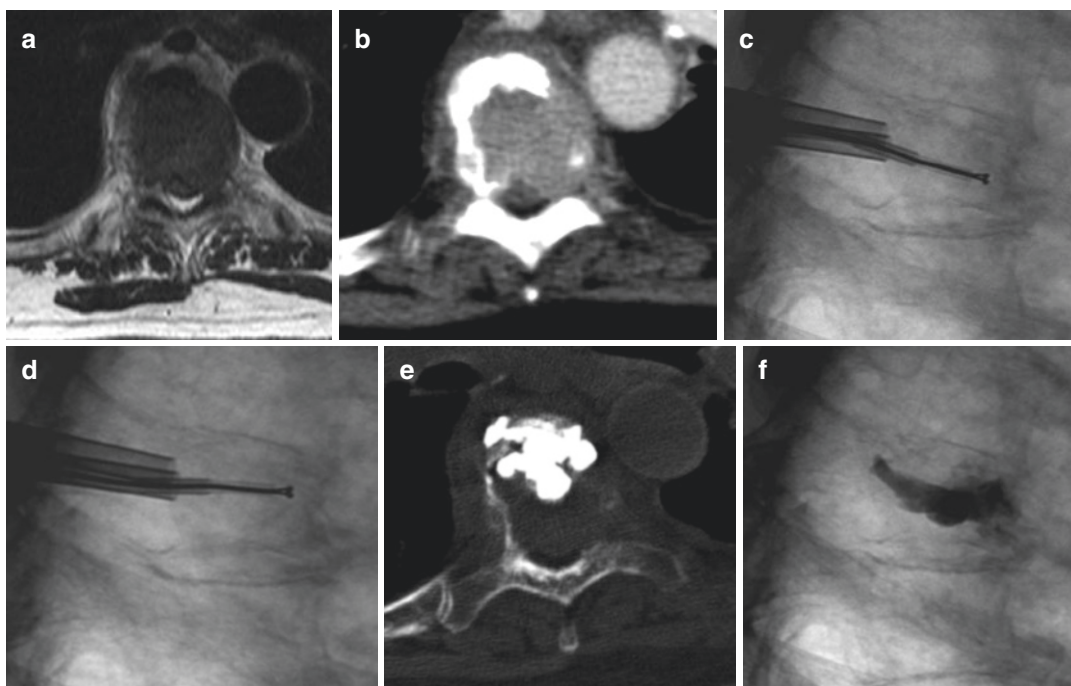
77 year old female with T5 metastatic melanoma. (a) and (b) are axial T1-weighted images (a) of T5 vertebra showing a large metastatic lytic lesion with destruction of the posterior wall and epidural extension. (b) is the corresponding CT image. (c) and (d) are selected lateral fluoroscopy
